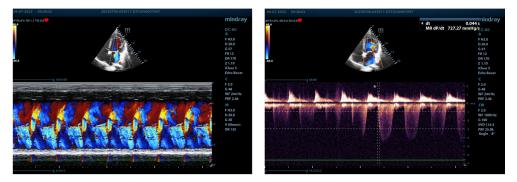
a.8. Left: holosystolic mitral regurgitation (M-color mode, 4-chambers view); right: calculating dP/dT = 727 mmHg/sec (CW Doppler, 4-chambers view)
